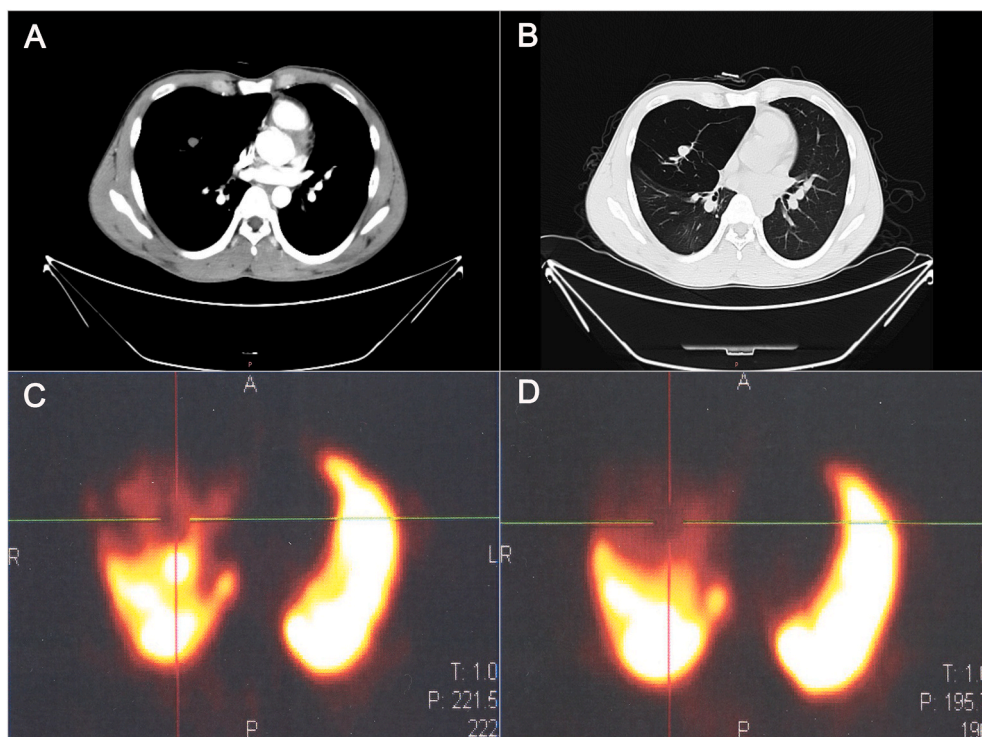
Contrast-enhanced CT performed on admission revealing (A) an 18mm × 11mm solitary, well-circumscribed, and solid nodule with no enhancement in the right upper lobe (RUL), and (B) emphysematous changes (e.g. increased transparency and decreased broncho-vascular shadow) distributed throughout the RUL. Lung ventilation (C) and perfusion (D) scan indicating sparse/defective radioactive distribution area in the anterior segment of RUL.
